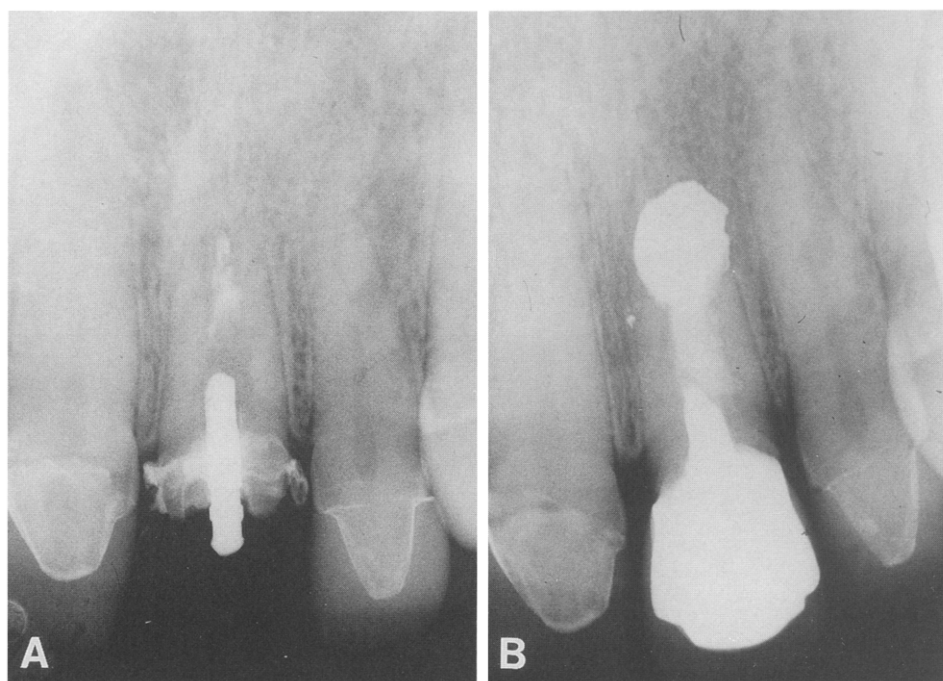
A, Preoperative radiograph of maxillary central incisor, incomplete canal filling, poorly fitting post, and periapical tenderness. B, The canal was prepared, refilled with gutta-percha, and apical surgery performed, including apicoectomy and the placement of an extremely large apical amalgam. This radiograph was taken 12 yr later, demonstrating excellent healing and no observable reaction to the amalgam.
